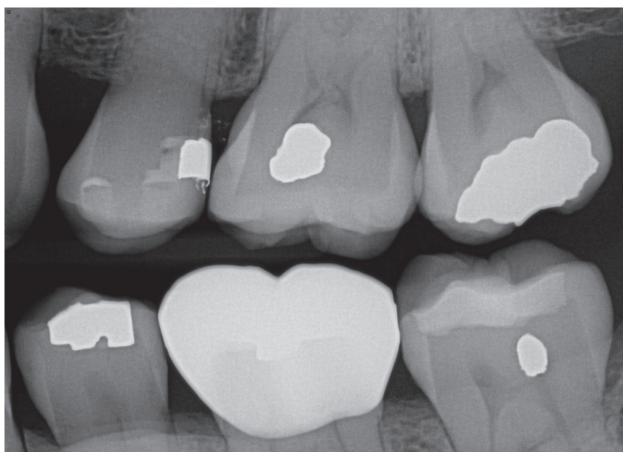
Radiograph showing the placement of the foil in the proximal box distal on tooth #13.
